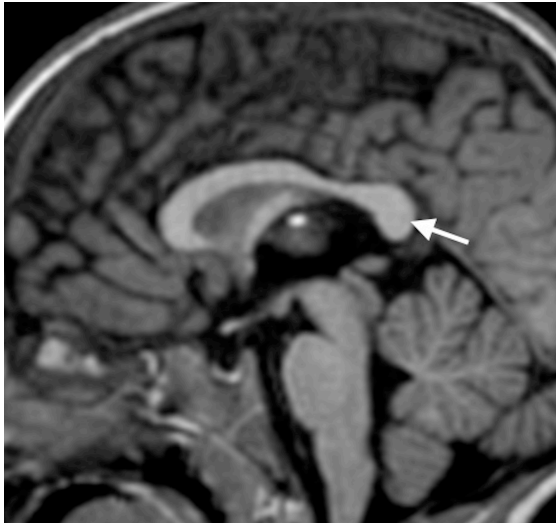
Midline T1 sagittal MRI scan demonstrates a diffusely thick corpus callosum in a 10-year-old male with ADHD and seizures
